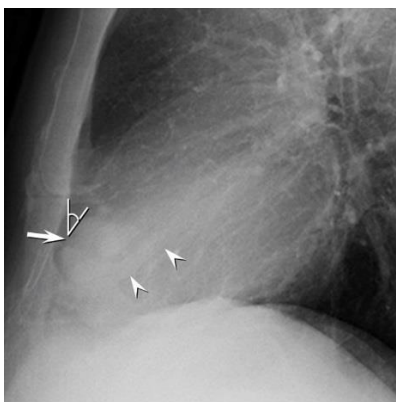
Detail image of the lateral chest radiograph shown in Figure 1 shows the circumscribed subpleural right middle lobe nodule (arrow); note how nearly the entire circumference of the nodule is visualized, and that the anterior margin of the lesion makes an acute angle (see angle) with the pleural surface / anterior chest wall, typical of a lesion located within the lung parenchyma. A faintly visualized tubular opacity (arrowheads) is seen extending towards the nodule.
